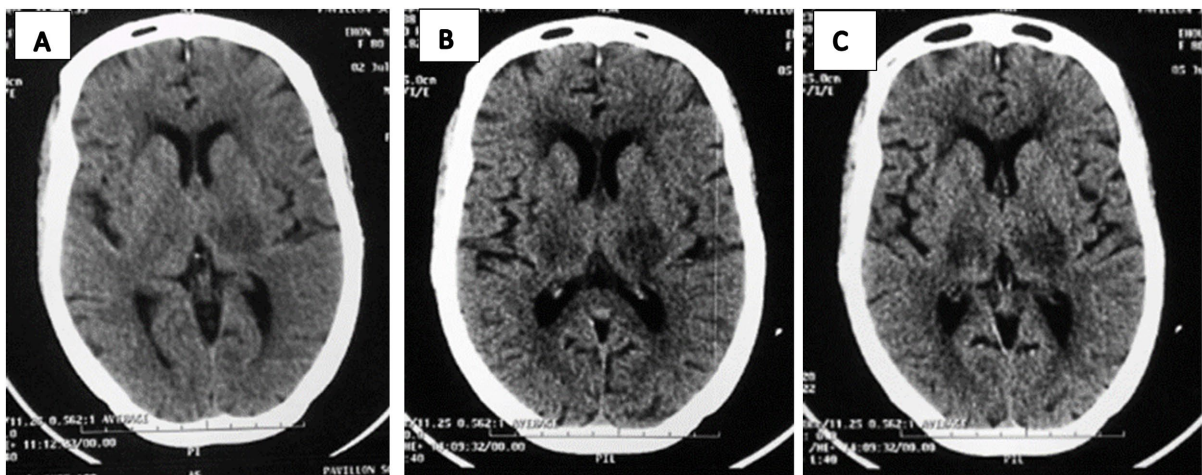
Brain CT showing an asymmetric bithalamic hypodensity at 4 hours (A) and, three days later, bilateral capsulo-thalamic hypodensities (B, C).
